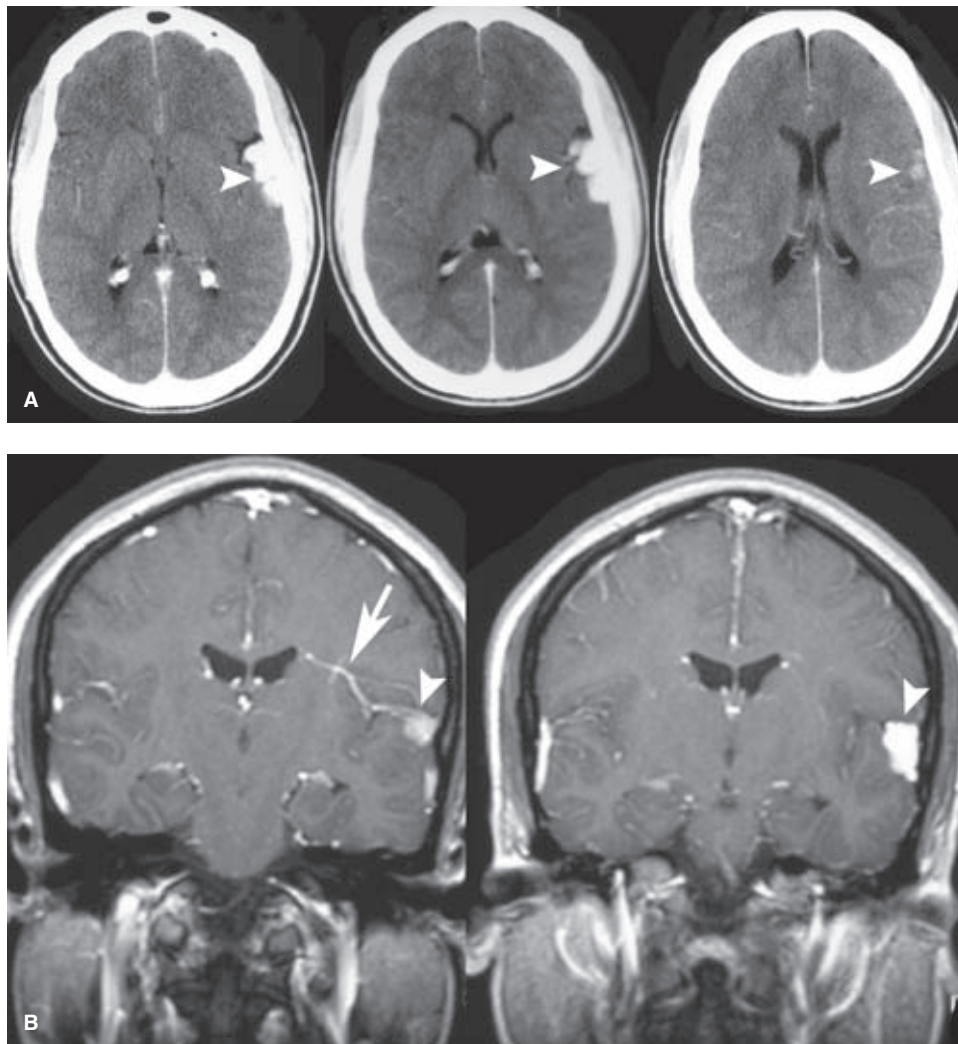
(A–B) Subarachnoid venous varix associated with anomalous veins. A 28-year-old female with complaints of headache was evaluated at another hospital and referred with a diagnosis of brain AVM. The CT scan with contrast (A) demonstrates a brightly enhancing structure in the left Sylvian region, which appears to be extra-axial (*arrowheads* in A). The contrast enhancement MRI confirms these findings and suggests that there are prominent intramedullary vessels (*arrows* in B) associated with this lesion. During the course of investigation, a left common carotid artery angiogram was performed to evaluate for the possibility of pial and dural disease together. (*continued*)
